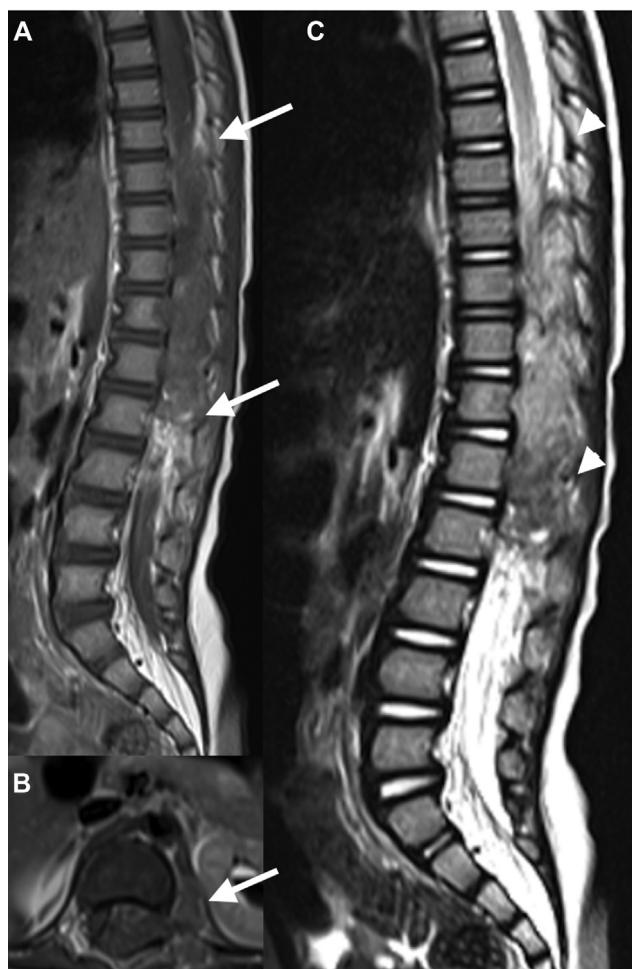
(A) Sagittal T1-weighted MRI scan with contrast showing a heterogeneously-enhancing epidural mass at T8-L2 (arrows); (B) axial T1-weighted MRI scan with contrast showing an extension to the left intervertebral foramen (L1 / L2) with a paravertebral mass and homogeneous enhancement (arrow); (C) sagittal T2-weighted MRI scan showing a heterogeneously-enhancing epidural mass at T8-L2 (arrowheads).
